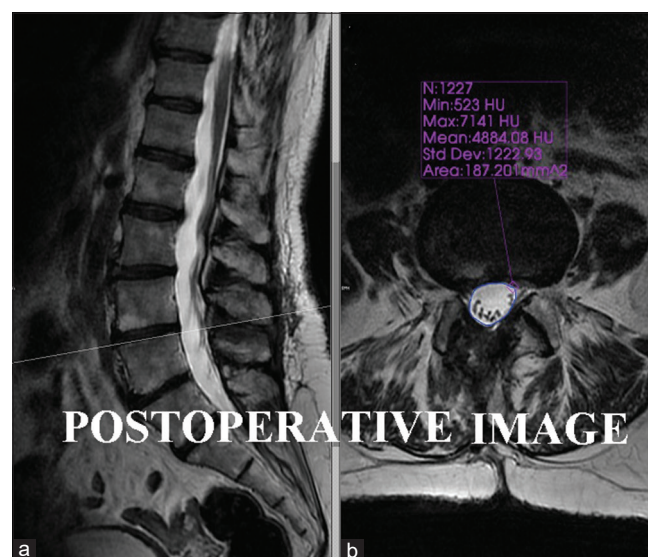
After suturing of PLL during surgery, (a) Sagittal, (b) Axial. Postoperative MRI of patient are seen; The intradural area was increased to 187.201 mm². PLL: Posterior longitudinal ligament
